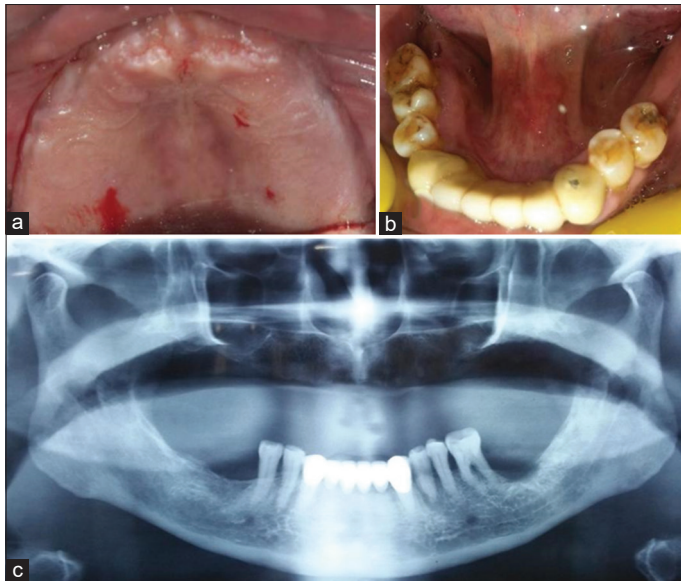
(a) Pre-operative (a) maxillary and (b) mandibular arch; (c) Pre-operative orthopantomogram
